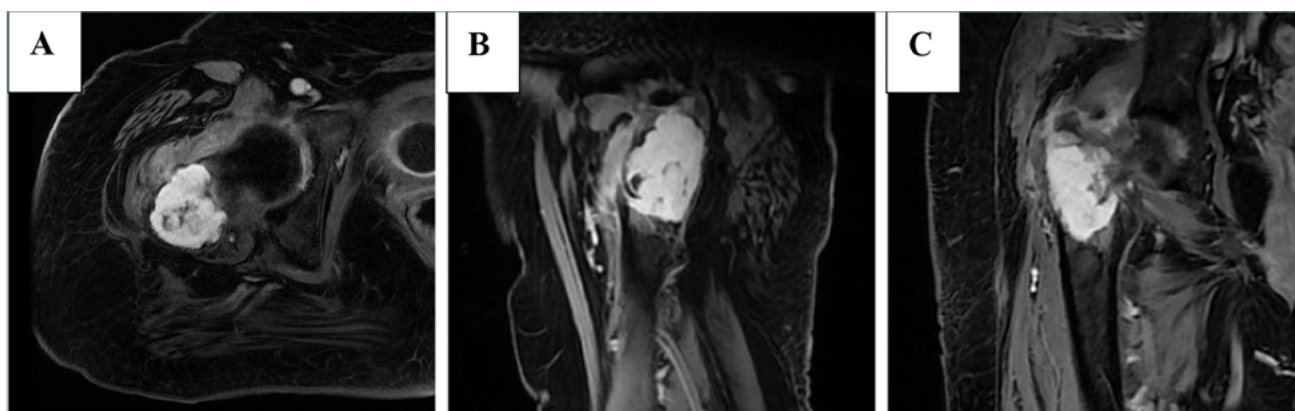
Axial (A), sagittal (B) and coronal (C) MRI sequences at the same level showing intense and homogeneous post-contrast enhancement of the bone lesion associated with perifocal oedema of the femoral neck spongiosa and of the muscular compartment associated to areas of cortical disruption.
